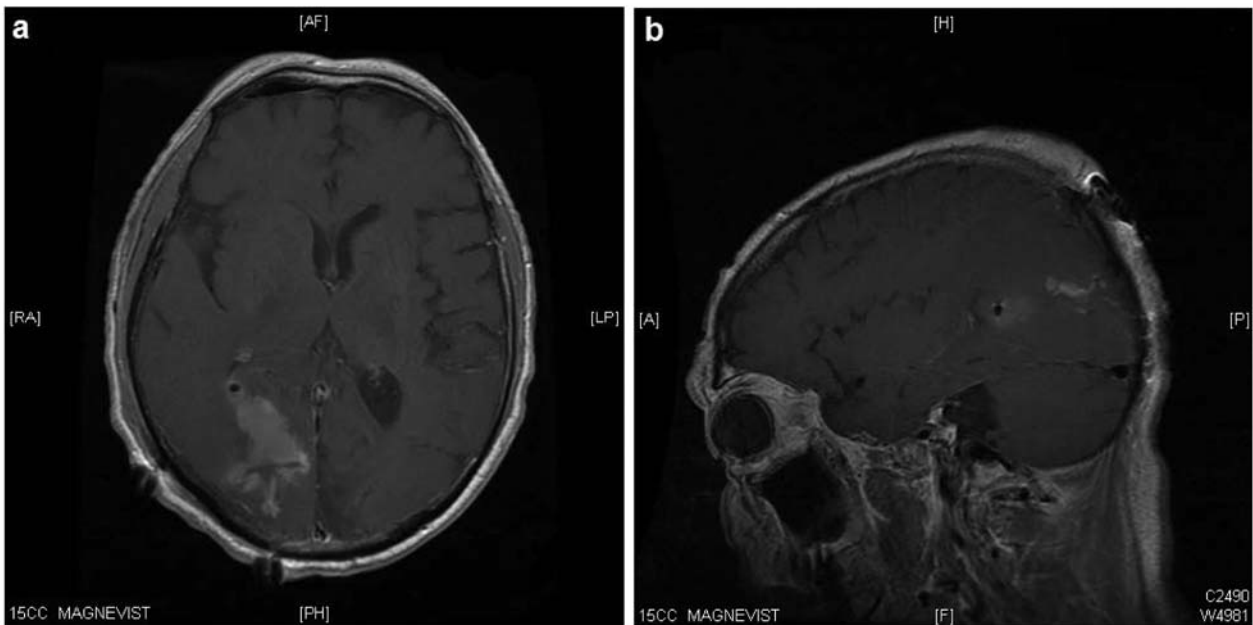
a: Axial postoperative MRI imaging with contrast. b: Sagittal postoperative MRI imaging with contrast (b).
